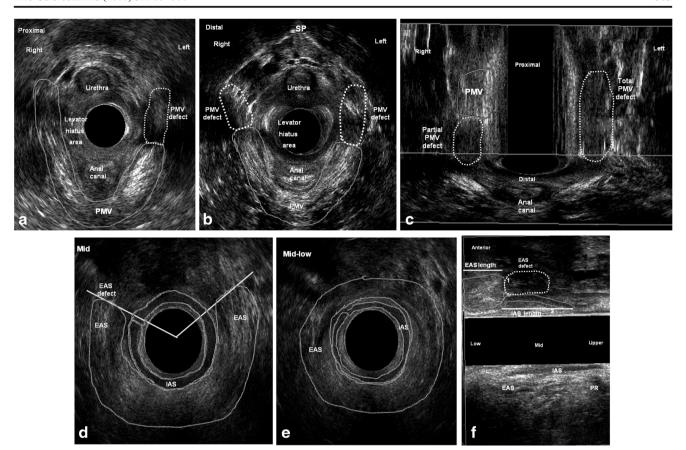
Representative three-dimensional ultrasonography images of bilateral pubovisceral muscle and partial external anal sphincter defects after vaginal delivery. a Endovaginal approach (axial plane) showing the pubovisceral muscle defect on the left side (proximal part). b Bilateral lesions of the pubovisceral muscle (distal part). c Complete defect of the pubovisceral muscle on the left and partial defect on the right side (coronal plane). d Mid anal canal, e mid-low anal canal. Anorectal
